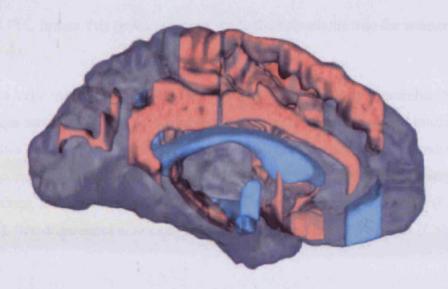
Sexually dimorphic brain structures. Data from Goldstein et al. (2001), where they measured the volume of brain regions relative to the cerebrum using MRI scans in 27 men and 21 women. Structures that are larger in women are shown in red and structures that are larger in men are shown in blue. Picture taken from Cahill (2006)
